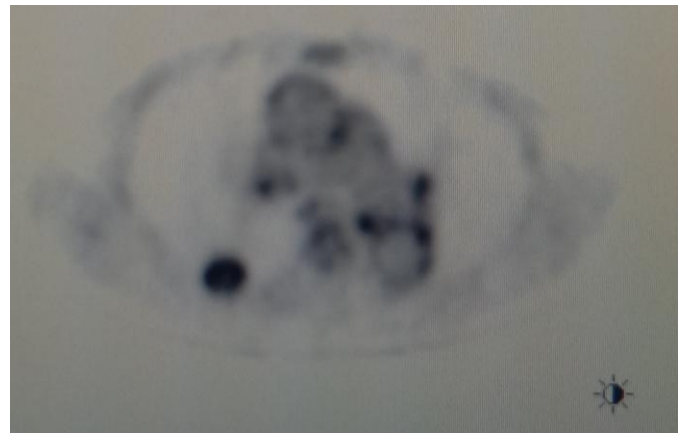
PET-CT. A nodular shadowing (23x18 mm) of the posterior bronchopulmonary part of the right upper lung lobe with (SUVmax :3.2).
